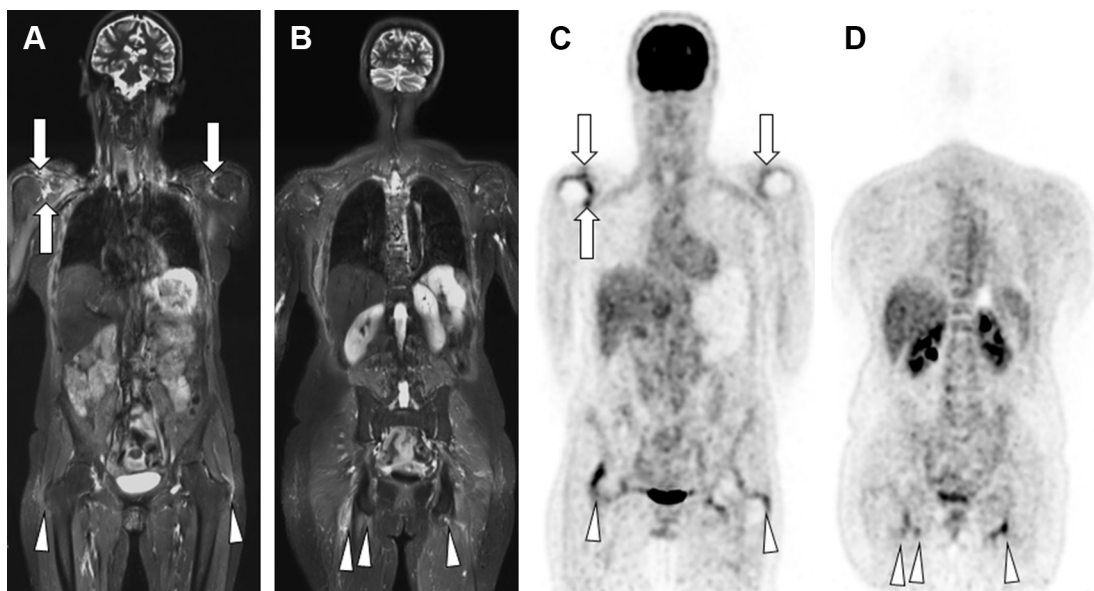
WB MR imaging from a 52-year-old female patient with polymyalgia rheumatica. Coronal STIR MR imaging (A, B) shows bilateral shoulder involvement with inflammatory infiltration of the periarticular soft tissues and synovitis (arrows in A), hip involvement with peritrochanteric infiltration (arrowheads in A), and bilateral ischiatic tenosynovitis/bursitis (arrowheads in B). Corresponding reformatted coronal views of 18-fluorodeoxyglucose PET images (C, D) show the same lesions.
